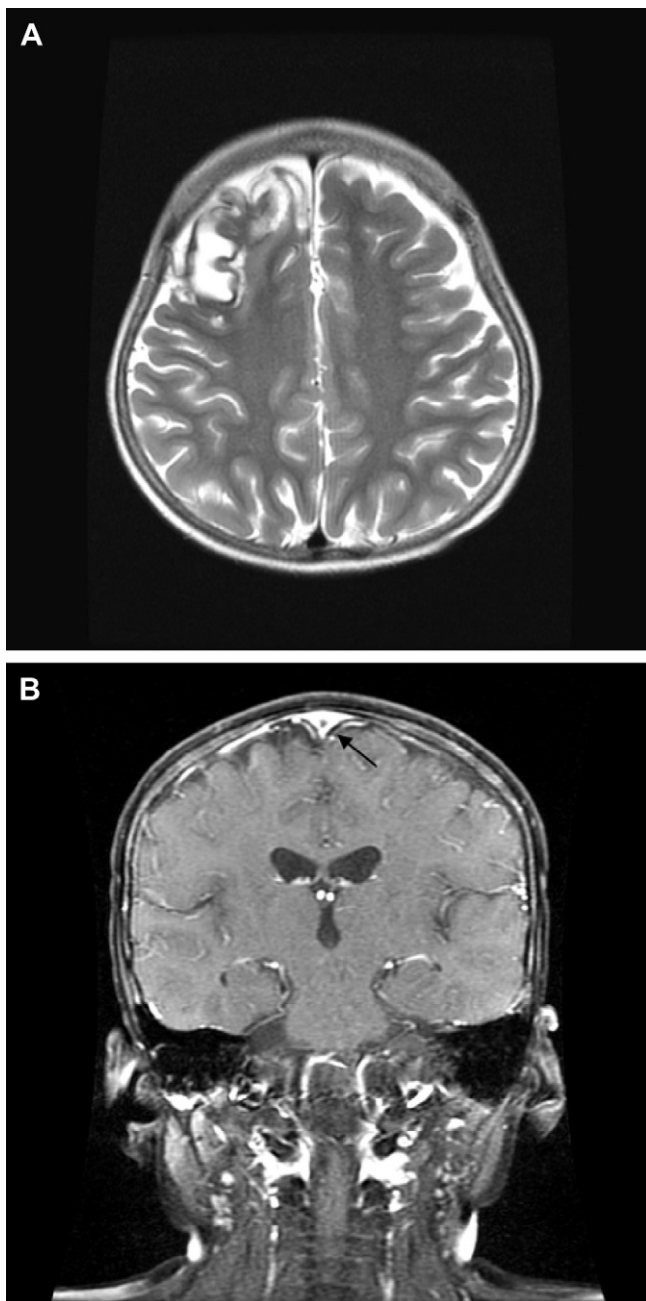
Three months after superior sagittal sinus thrombosis episode. (A) Axial T2-weighted magnetic resonance imaging shows that the bright-up on diffusion-weighted images was resolving gradually. (B) Coronal T1-weighted magnetic resonance imaging reveals resolution of the low-attenuating thrombus (arrow) within the superior sagittal sinus.
